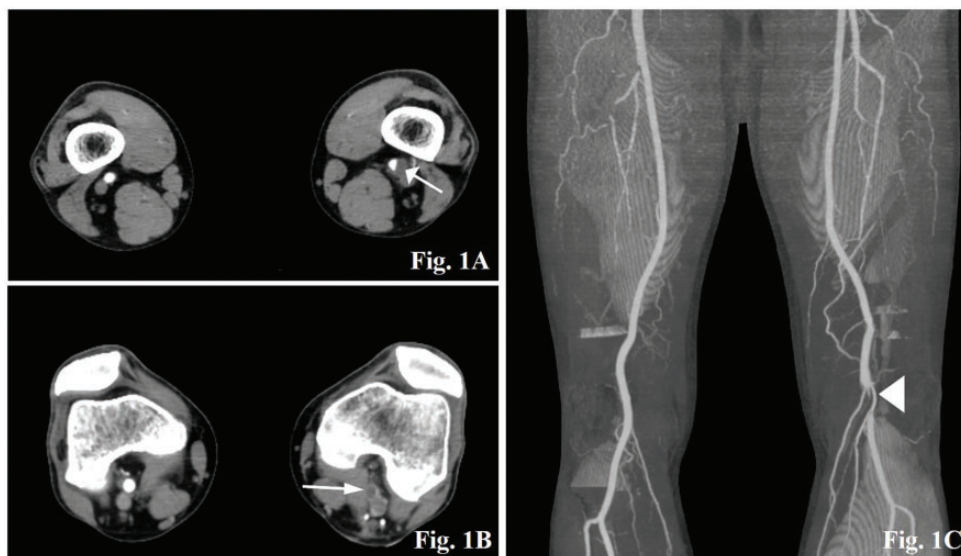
Computed tomography angiography (CTA) images of the lower extremity, showing: (a) preoperative initial axial image above the knee revealing a cystic mass (white arrow) compressing the left popliteal artery; (b) repeat CTA image performed 3 months after cyst excision and patch angioplasty, revealing near-complete occlusion of the popliteal artery at the level of the knee (white arrow) and normal right popliteal artery; and (c) coronal maximal intensive projection image, also performed at 3 months after cyst excision and patch angioplasty, revealing short-segment non-opacification of the left popliteal artery at the level of the knee (white arrowhead).
